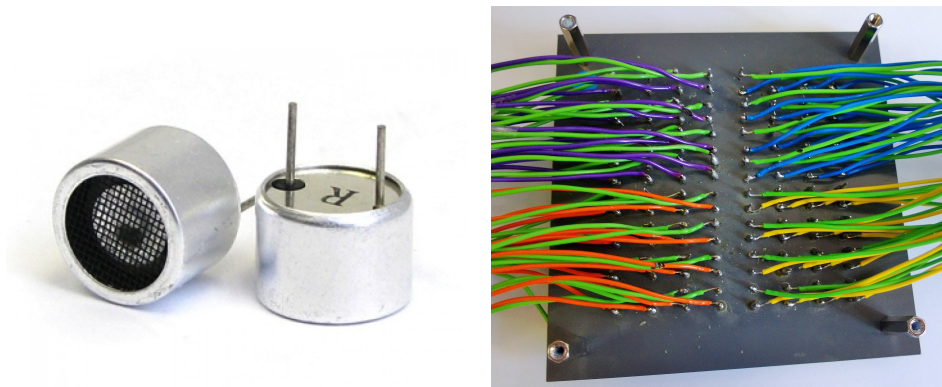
The Mini Array consisting of 8x8 (64 piece) ultrasonic transducers
